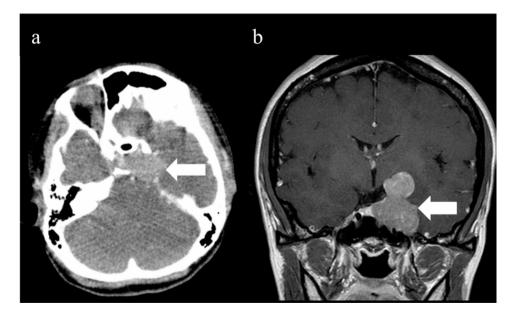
CT revealed a mass in the left side of the sella turcica (a: arrow). Coronal contrast-enhanced T1-weighted images of the pituitary gland revealed the mass as a pituitary adenoma invading the left cavernous sinus and displacing the left temporal lobe (gradient echo; TR/TE, 20/4.82 ms) (b: arrow)
